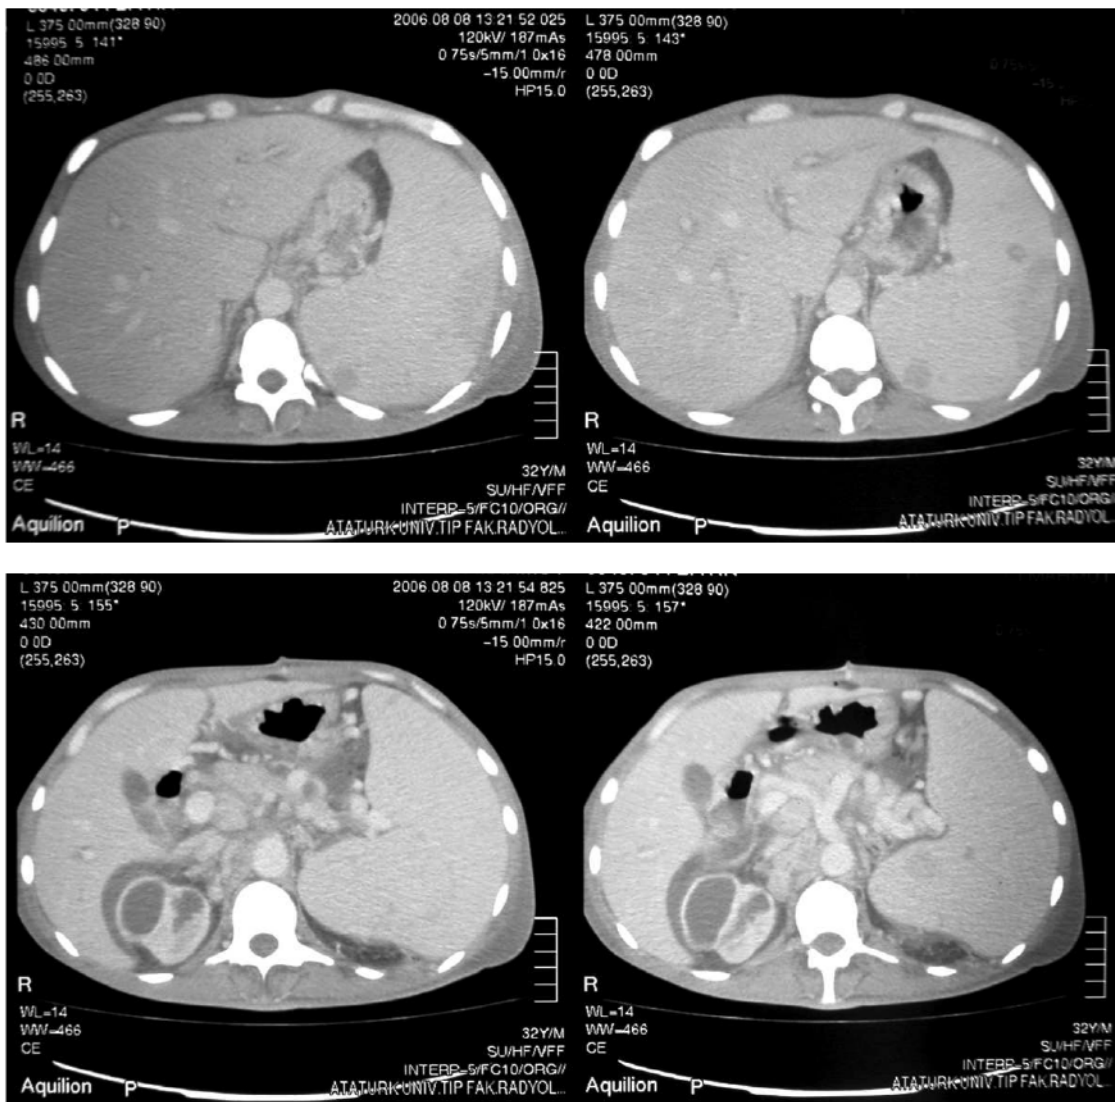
Computed tomography of the abdomen shows multiple paraaortic conglomerated lymphadenopathies, large liver of 200 mm, extremely large spleen 290 mm in size, necrotic infarct areas in upper and lower poles of the spleen, hypodense lesions in the spleen, and 20 mm-sized lymphadenopathy anterior to liver.
